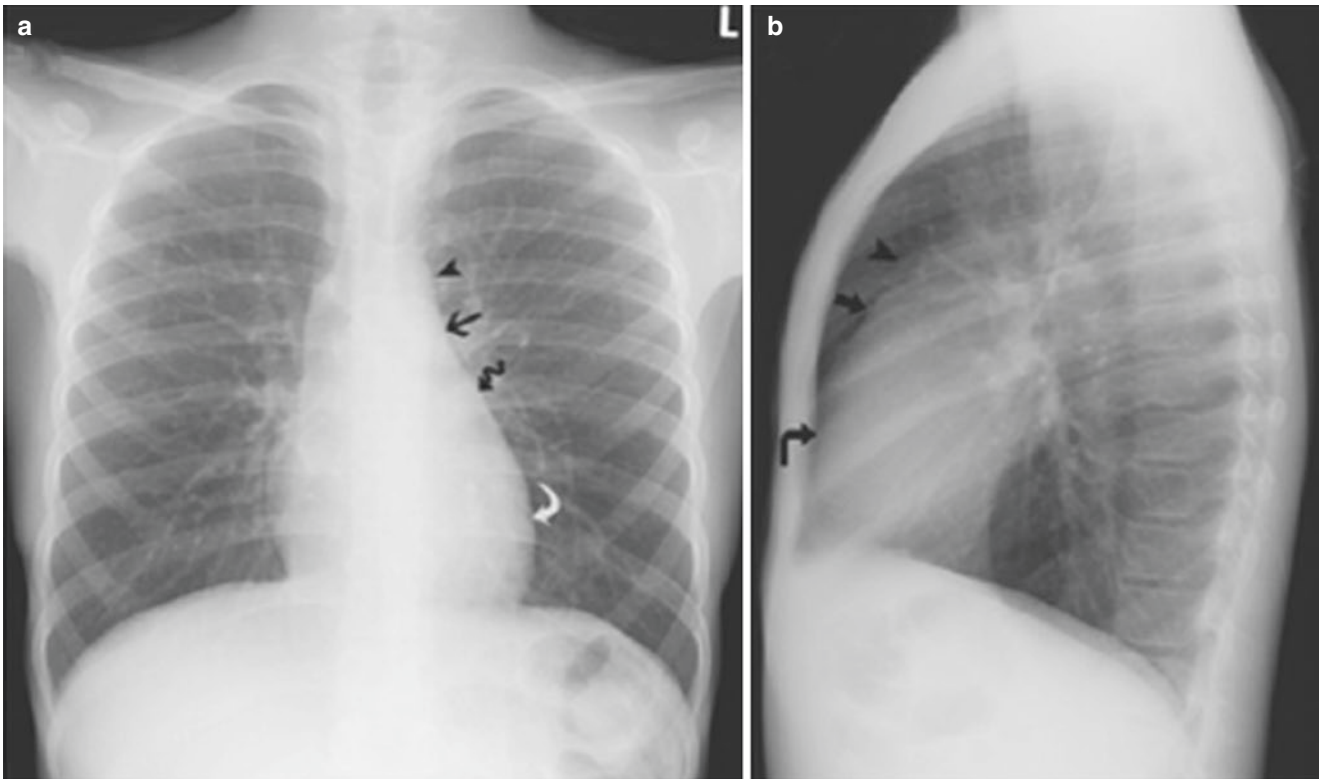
(a, b) Normal PA and lateral radiographs of the chest in a 10-year-old
